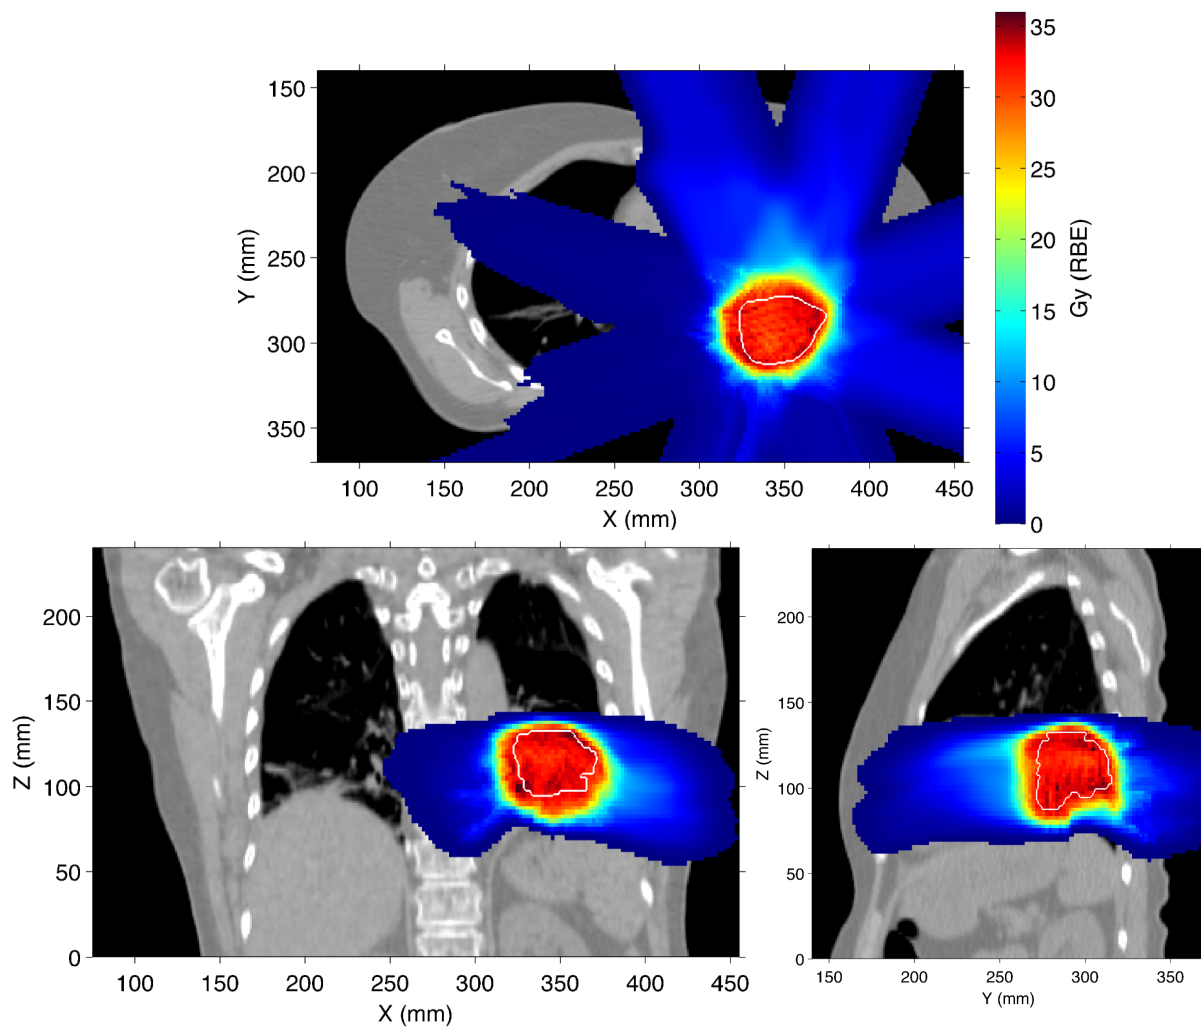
4D RBE-weighted dose distributions overlaying CT images for the reference case of perfect beam tracking for Lung Patient #1 with axial (top), coronal (bottom left), and sagittal (bottom right) views. 4D RBE-weighted dose and CT data are shown in the reference motion state at end-exhale. The CTV boundary is indicated by the white curve. The prescribed target dose was 32.8 Gy (RBE). This plot shows the treatment plan but does not contain information about robustness.
